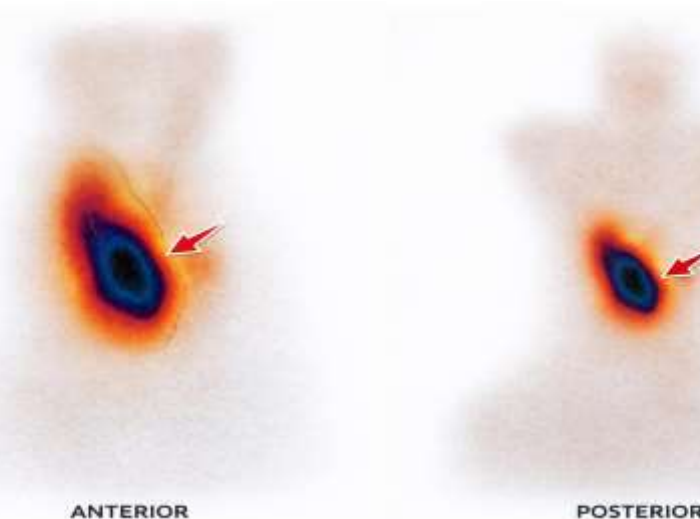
Anterior thyroid scintigraphy: diffuse increased uptake uptake in the right thyroid lobe with a focal hypo functioning nodular area . Residual uptake in the left thyroid bed is consistent with thyroid remnant after prior lobectomy
